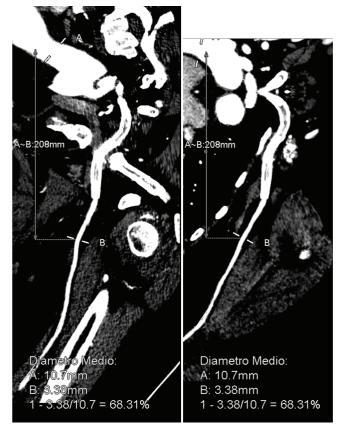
CT angiography showing the close relationship between the vascular prosthesis and the bony fragments.
